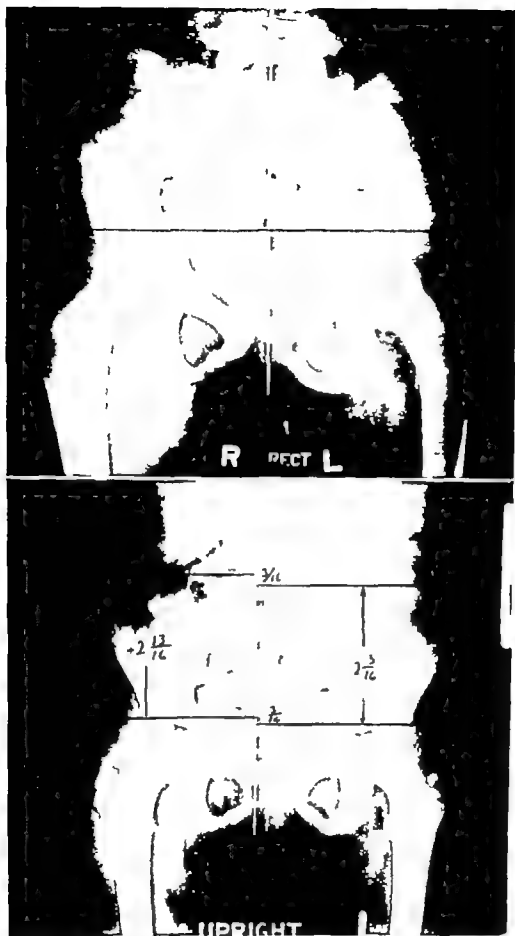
Measurement of Leg Length Difference in Children. A (Upper) Anteroposterior radiograph—L.C. Age 12—left leg one-half inch short. B (Lower) Anteroposterior radiograph—P.G. Age 3—left leg $\frac{7}{32}$ inch short.
